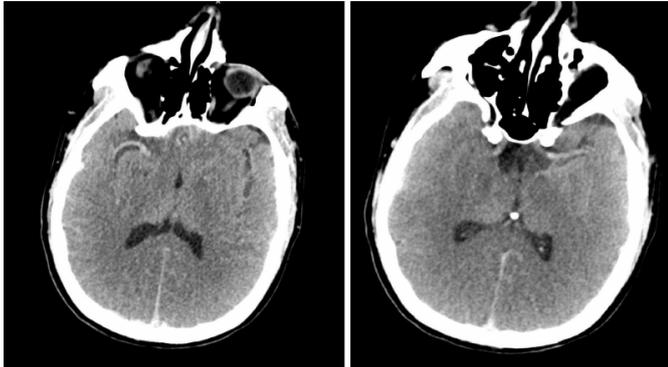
Non enhanced axial CT images: The middle cerebral arteries (MCA) are dense. The right MCA is well seen in right image and the left MCA in left image.
